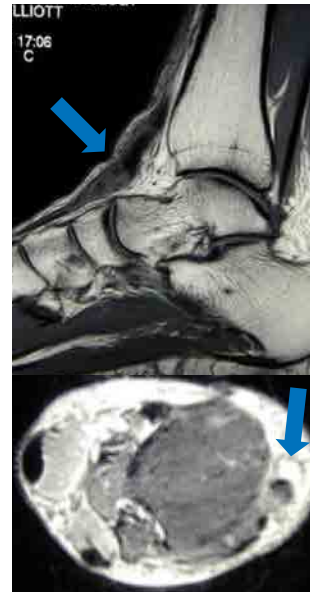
MRI of the right foot/ankle showing rupture and retraction of the anterior tibial tendon
